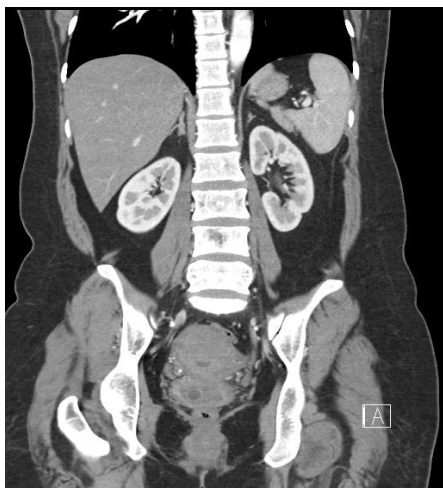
preoperative CT image shows small cystic mass at posterior cervix-vaginal area
